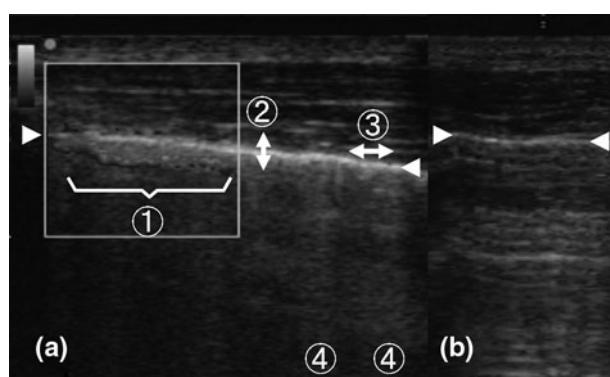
Two-dimensional (2-D) US images. White triangles indicate the pleural line. a Normal lung: ① power sliding; white box indicates an area of interest with the color power Doppler area; ② lung pulse (motion of the lung/wall interface is only visible in real time); ③ lung sliding (same as above); ④ comet tail artifact arising from the pleural line and heading deeper. b Pneumothorax case: the pleural signs described above are absent and several horizontal reverberations can be seen in the background
